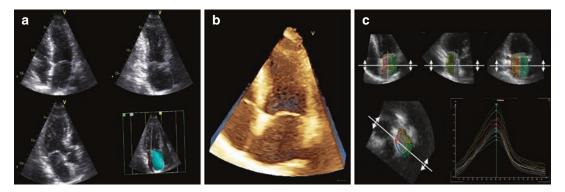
RT3DE measurements of LA volume. 3D-guided triplane images may be used to obtain improved anatomical alignment of the apical 4-, 2-, and 3-chamber views (panel a). The blood tissue interface may be then traced to obtain maximum and minimum LA volumes, as well as ejection fraction. Live-3D may also be used to
